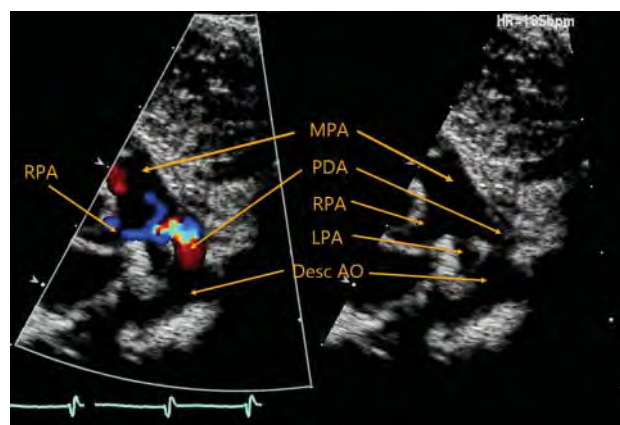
High left parasternal echocardiographic long-axis view of the cardiac vessels demonstrating the relationship of the PDA to the main pulmonary artery (MPA), left pulmonary artery (LPA), right pulmonary artery (RPA), and descending aorta (Desc Ao).
